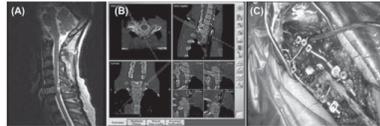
(A) MRI of the cervical spine showing an extradural tumour compressing spinal cord. (B) Pedicle finder advanced under image guidance. (C) Intraoperative view of final construct.
